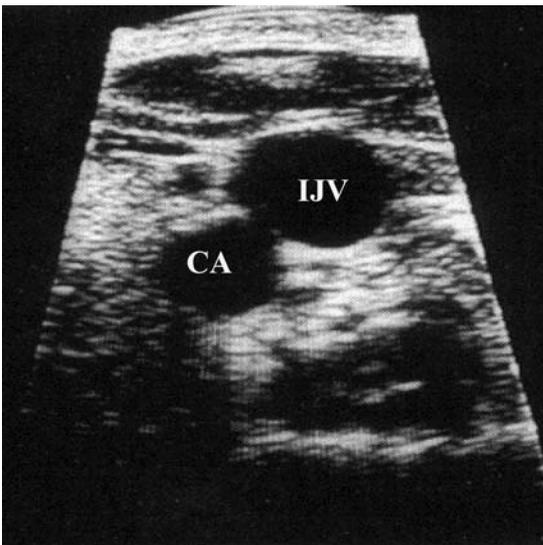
Ultrasound image of CA and IJV. *Abbreviations:* CA, carotid artery; IJV, internal jugular vein.
